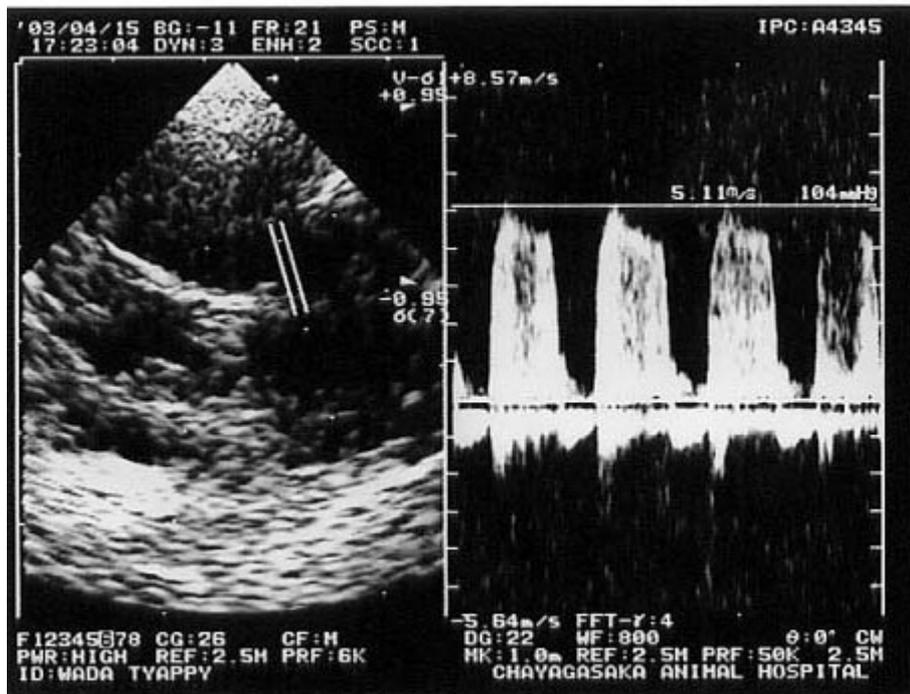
Continuous wave Doppler echocardiography at the pulmonic valve. The peak pulmonary regurgitation velocity was 5.1 m/s, and the diastolic pulmonary arterial pressure was 104 mmHg. This indicates severe PH.
